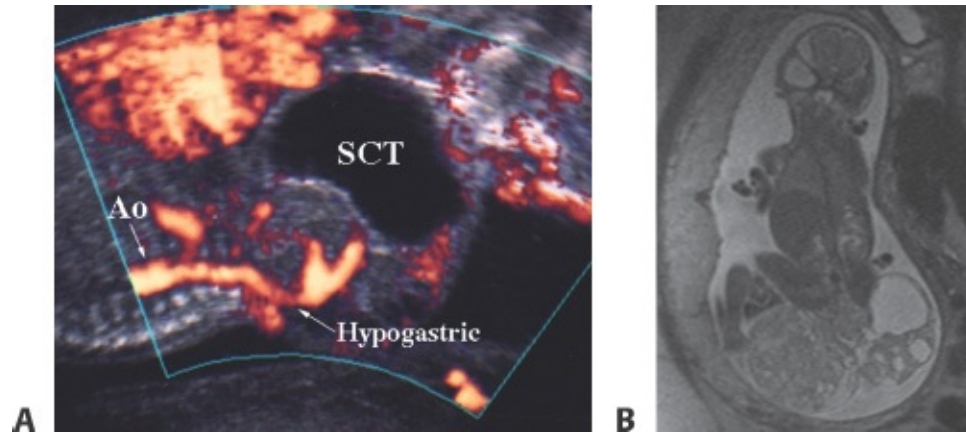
• Prenatal SCT imaging. A. High-resolution fetal ultrasound demonstrating a predominantly cystic type I SCT with blood supply originating from the hypogastric vessel. B. Ultrafast fetal MRI demonstrating a large type I SCT that has solid and cystic components.
